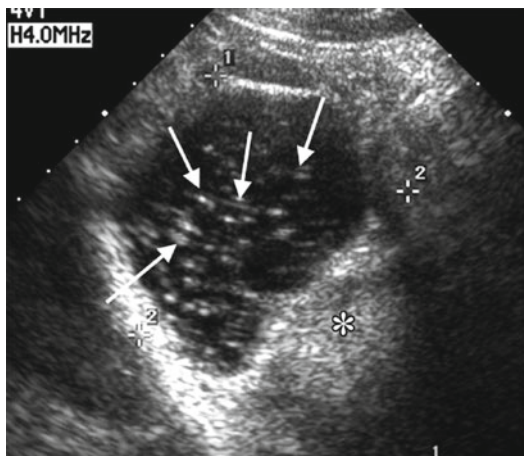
Teratoma ultrasound study (note the echogenic linear speckles). (*asterisk*) shows echogenic mass, (*arrows*) shows echogenic linear speckles
